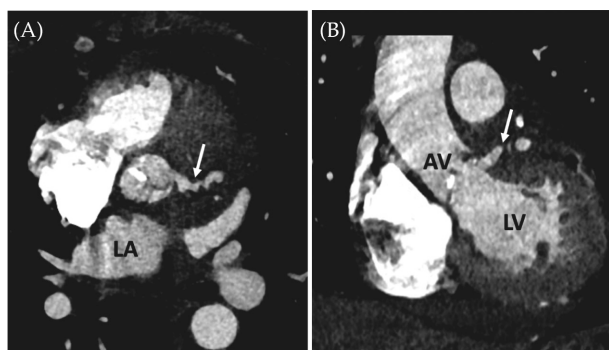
Short axis (A) and long axis (B) cardiac computed tomography slices demonstrating a subaortic pseudoaneurysm originating from the left ventricular outflow tract (arrow). AV: aortic valve, LA: left ventricle, LV: left ventricle.
